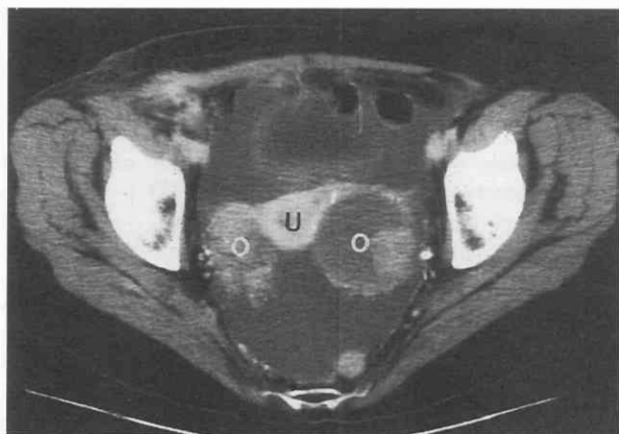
Bilateral ovarian cancers. CT scan through the uterus (U) shows solid right and cystic and solid left ovarian cancers (O) surrounded by ascites.
